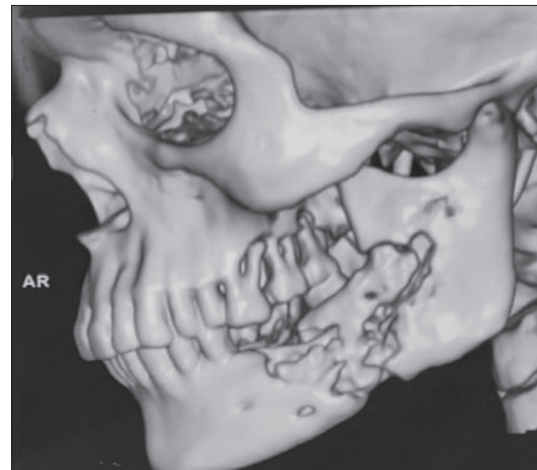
3D CT scan showing necrotic bone, causing a pathological fracture
